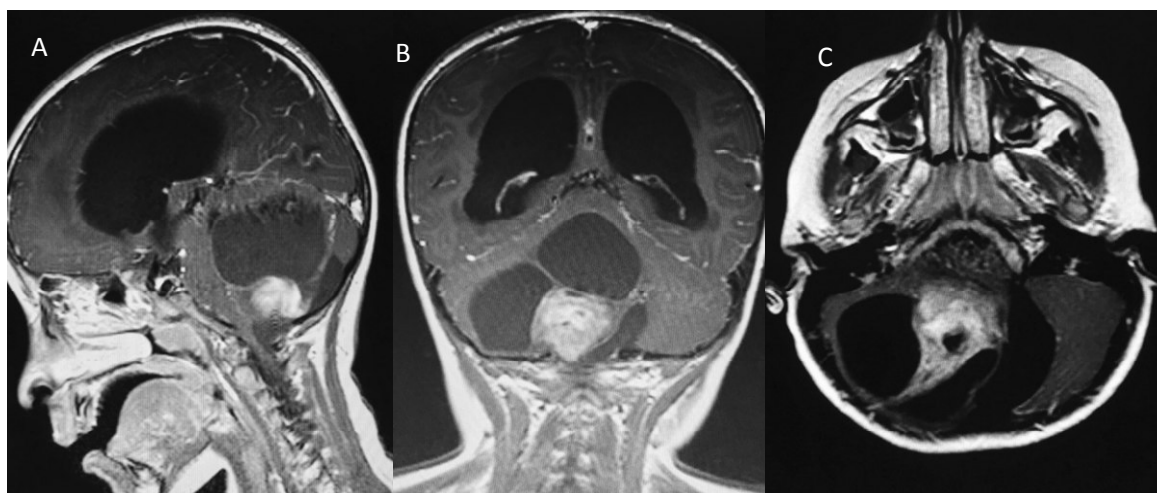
T1 contrasted sequence of brain MRI in A) sagittal, B) coronal, and C) axial planes, showing a markedly enhanced posterior fossa tumor surrounded by a large cyst with a severe obstructive hydrocephalus.
